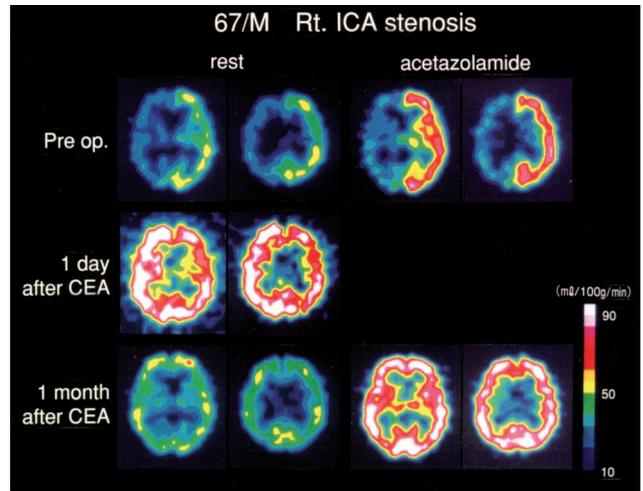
A case of hyperperfusion with severe right (Rt.) carotid stenosis. Top, Preoperative SPECT. Severe hypoperfusion is seen in the right ICA territory on resting SPECT. Almost no CBF response to acetazolamide is seen in the same territory, and intracerebral steal is seen in the right frontotemporal area (33.4 to 31.8 mL/100 g per minute, ie, -4.8% reduction). Middle, SPECT on the first postoperative day clearly demonstrates hyperperfusion (>90 mL/100 g per minute) in the right ICA territory. Moderate CBF increase is also seen in the left ICA territory. Bottom, SPECT 1 month after CEA. Preoperative hypoperfusion and CBF response to acetazolamide return to normal, with complete resolution of the lateralized hyperperfusion seen on SPECT on the first postoperative day. Rainbow displaying CBF from 0 to 90 mL/100 g per minute appears on the right.
